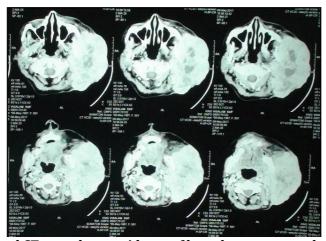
Contrast enhanced CT scan shows evidence of large heterogeneously enhanced lesion with multiple hypodense area noted with epicentre with left deep and superficial lobe of patrotid gland.
